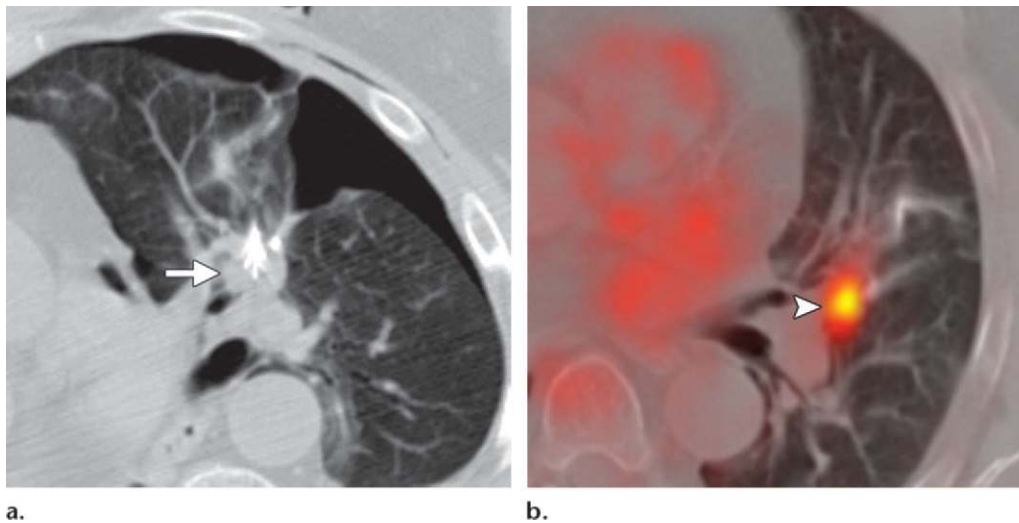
Metastatic renal cell carcinoma in a 68-year-old woman. (a) CT image shows that the medial nodular edge of the metastasis (arrow) is too close to the bronchus and is subject to the heat sink effect. (b) PET/CT image obtained at 3-month surveillance shows a focal area of recurrence (arrowhead).
